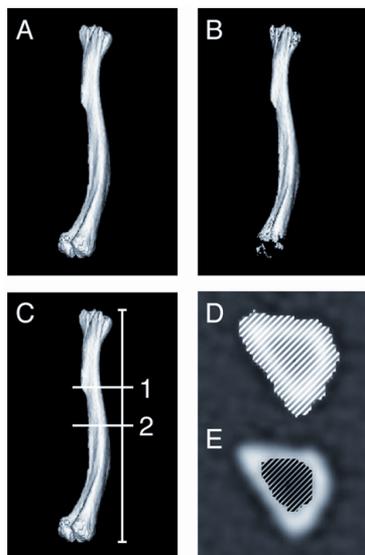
Definition of measured CT variables: (A) Total bone volume (mm^3) and vBMC (mg/cm^3). (B) Cortical bone volume (mm^3) and vBMC (mg/cm^3). (C) Total straight and curved length (mm). (D) Periosteal area (mm^2), i.e., the cross-sectional area delineated by the outer circumference and (E) endosteal area (mm^2), i.e., the cross-sectional area delineated by the inner circumference at (C1) fibula-site and (C2) mid-shaft of tibia.
